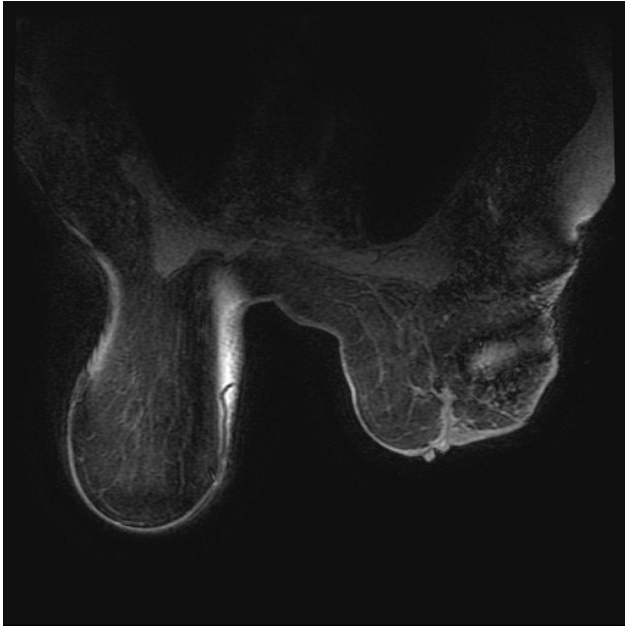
Postoperative MRI image of Case 1.
